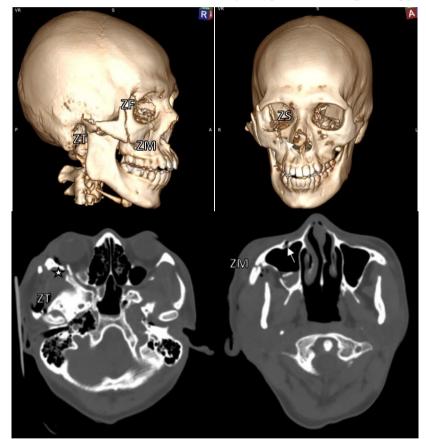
A 22 years old male post motorcycle accident. On Head CT-scan axial and 3D reconstruction, on 3D reconstruction we can see the disruption of zygomaticofrontal (ZF), zygomaticosphenoid (ZS), zygomaticomaxillary (ZM) and zygomaticotemporal (ZT) suture which shows a case of ZMC fracture. On axial view, we can also see fractures of the anterior maxillary sinus wall (arrow) and that the defect of the ZS suture is caused by comminuted fracture of the right lateral orbital wall (\Rightarrow) with the fragments medially displaced which is a case of blow-in right orbital fracture.
